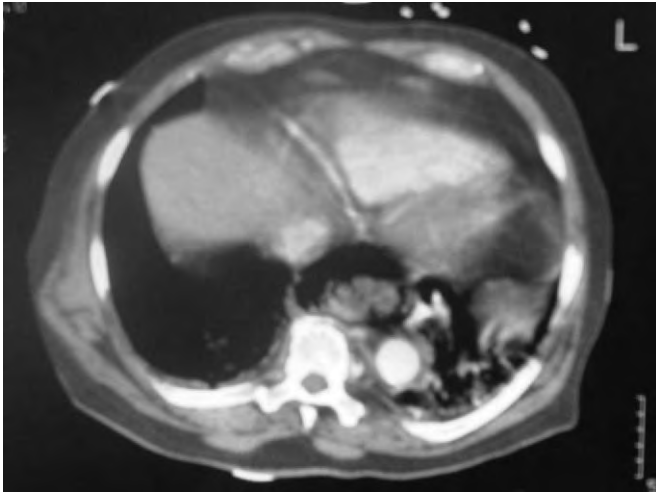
Abdominal computed tomography scan revealing mediastinal air and pneumothorax secondary to thoracic esophageal perforation.
